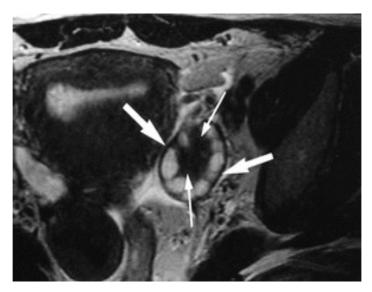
43-year-old woman with ovarian serous cystadenofibroma. Axial T2-weighted (TR/TE, 2,000/80) (A), axial T1-weighted (600/15) (B), and axial contrast-enhanced T1-weighted (C) MR images show cystic lesion with solid nodular area (*thin arrows*) surrounded by thickened septa and wall with moderate enhancement (*thick arrows*).
